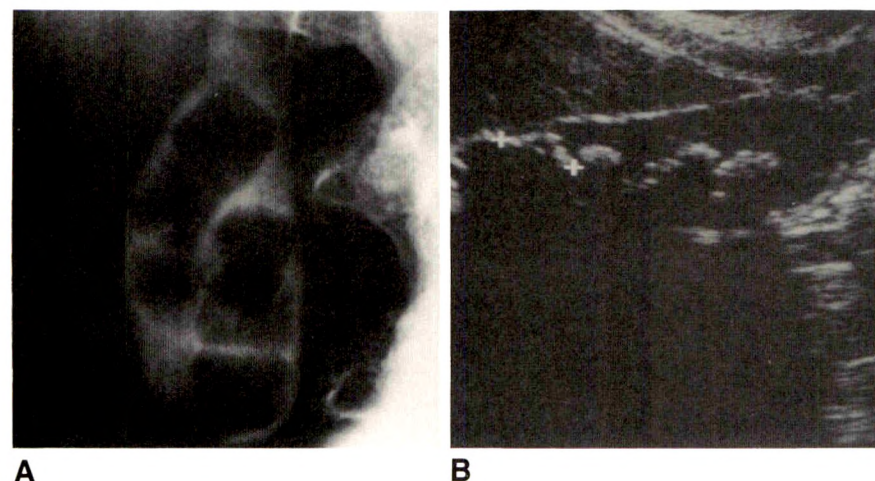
Cholecystographic-sonographic correlation. Oral cholecystography better shows size, shape, and number of stones.
